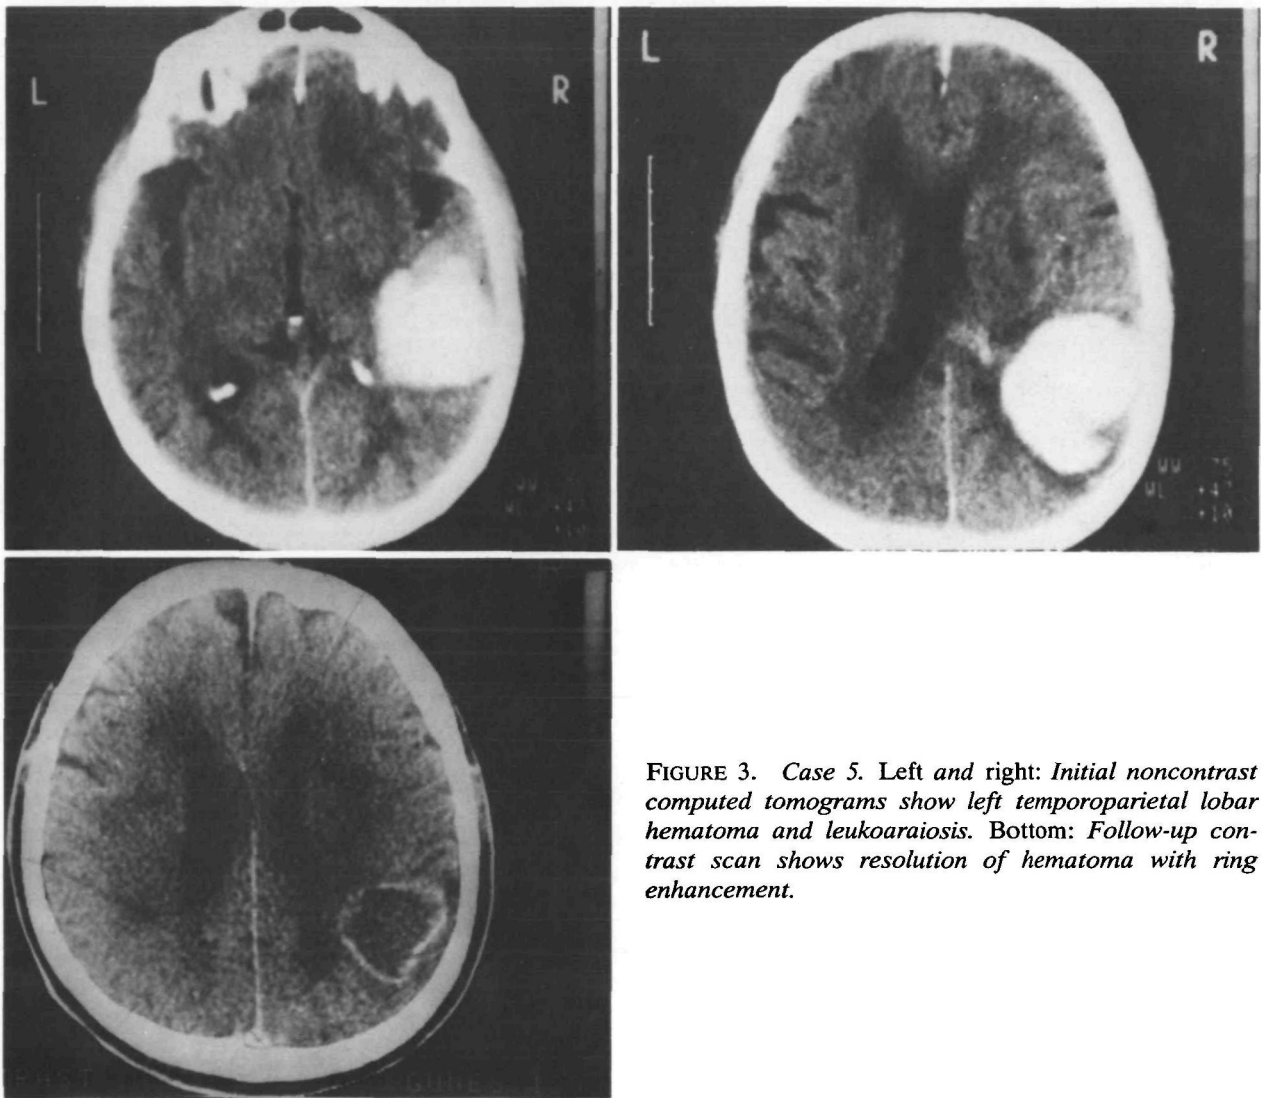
Case 5. Left and right: Initial noncontrast computed tomograms show left temporoparietal lobar hematoma and leukoaraiosis. Bottom: Follow-up contrast scan shows resolution of hematoma with ring enhancement.
